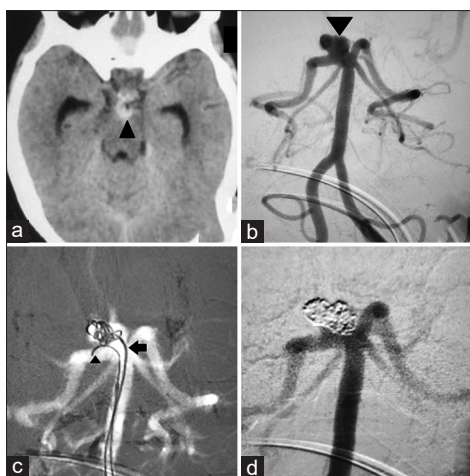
Brain CT shows crescent-shaped hyperintensity in the anterior aspect of pons and hyperintensity in peripontine cistern suggestive of basilar tip aneurysm with subarachnoid hemorrhage (a); digital subtraction angiography after vertebral artery injection showing broad-based dissected pseudoaneurysm in P1 segment (b); DSA roadmap showing two microcatheter, through one of them a microwire is hinged at right P1 segment (black arrowhead) and the other being used for coiling of the dissecting aneurysm (black arrow) (c); final check DSA showing near total obliteration of the aneurysm with patent right posterior cerebral artery (d)
